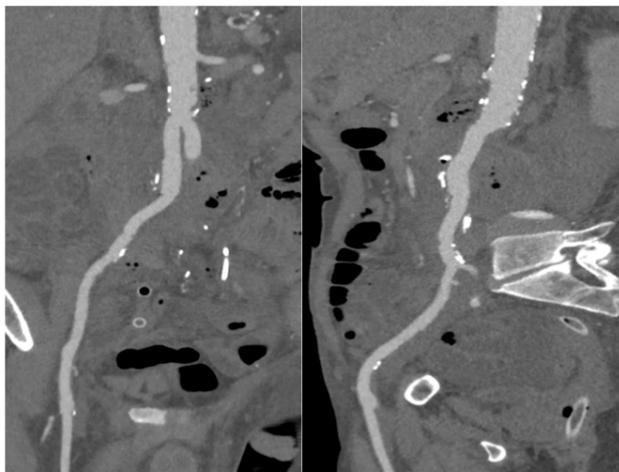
Angio-computed tomography scan of control at first month of postoperative treatment surgical showing no complications.
